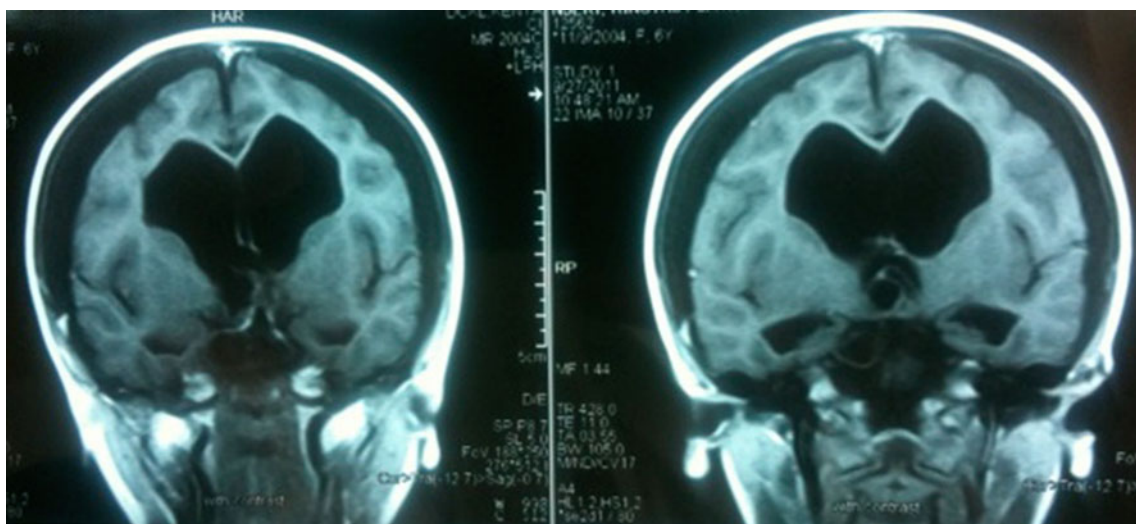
Pre-operative coronal CT scan demonstrating the multi-cystic craniopharyngioma and associated hydrocephalus
